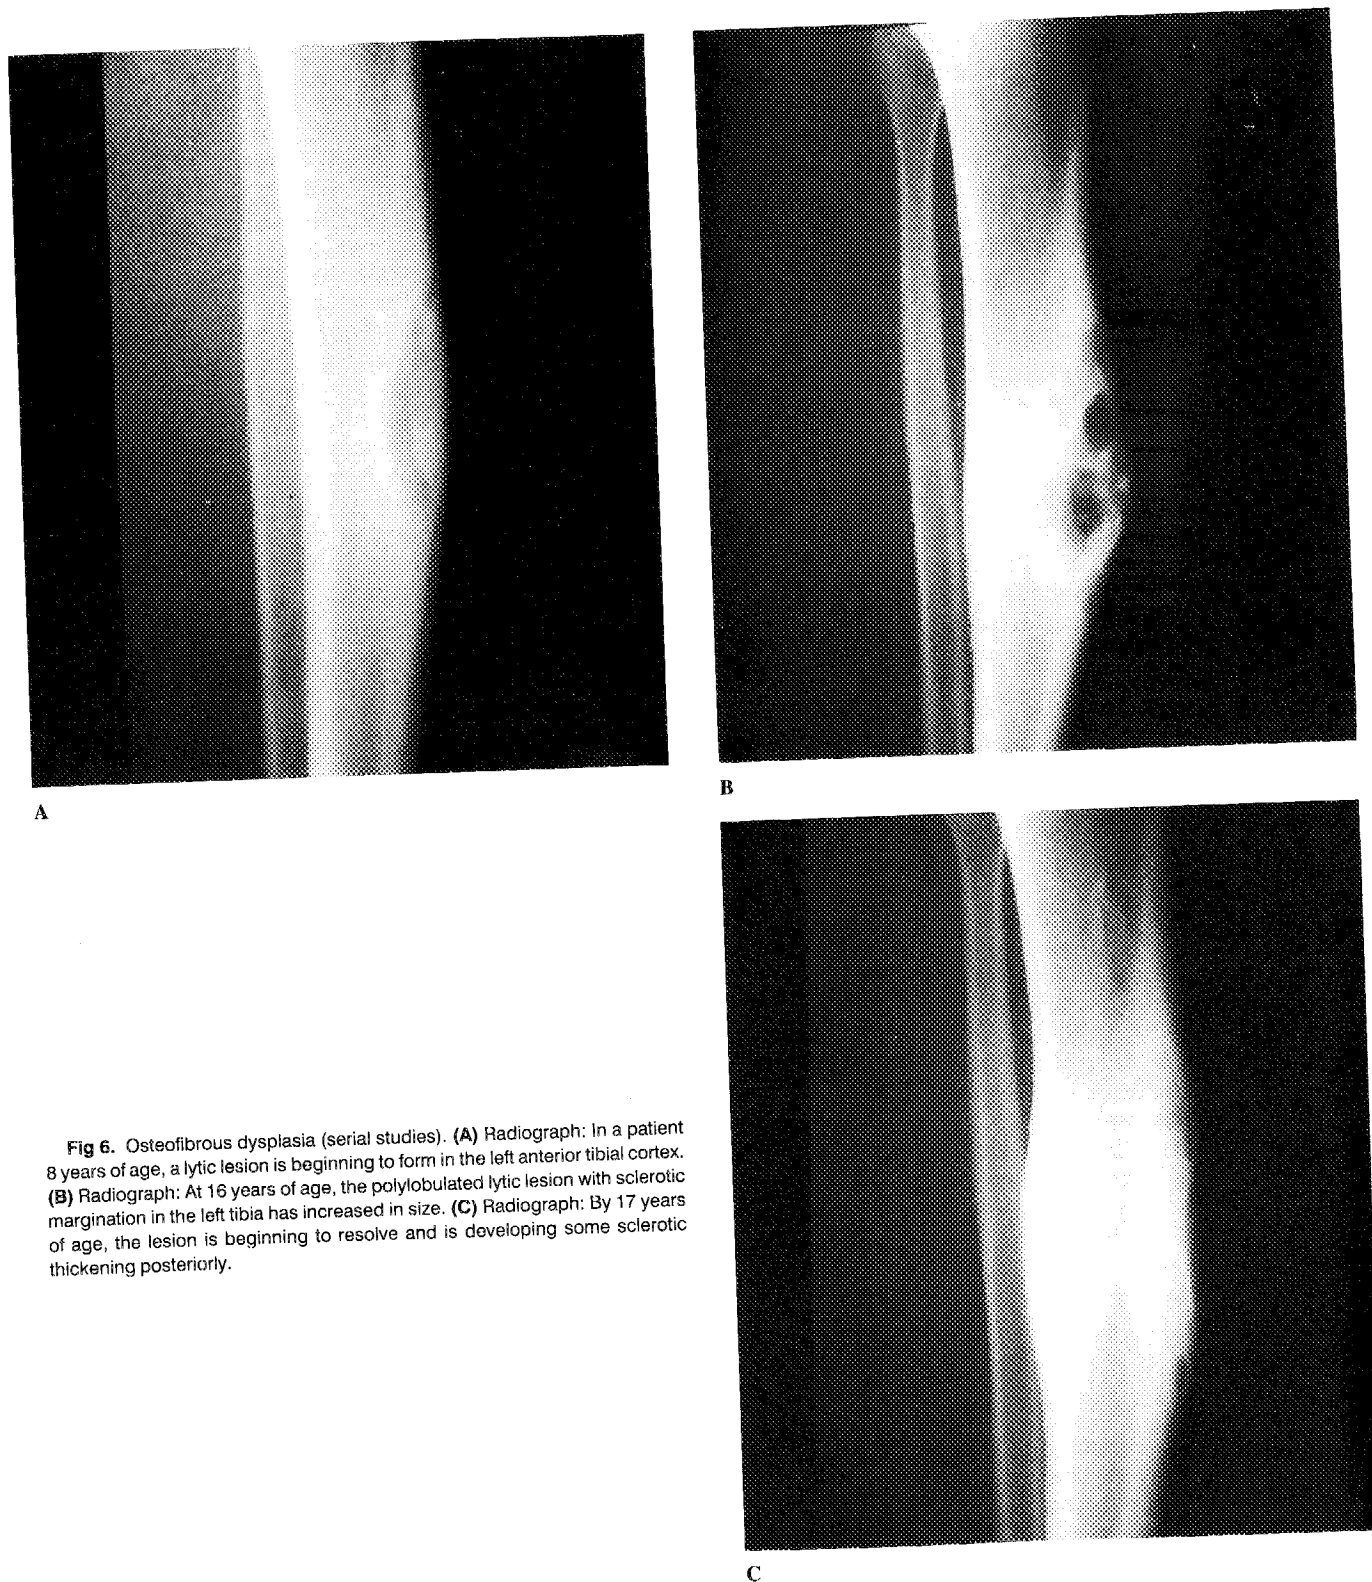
Osteofibrous dysplasia (serial studies). (A) Radiograph: In a patient 8 years of age, a lytic lesion is beginning to form in the left anterior tibial cortex. (B) Radiograph: At 16 years of age, the polylobulated lytic lesion with sclerotic margination in the left tibia has increased in size. (C) Radiograph: By 17 years of age, the lesion is beginning to resolve and is developing some sclerotic thickening posteriorly.
